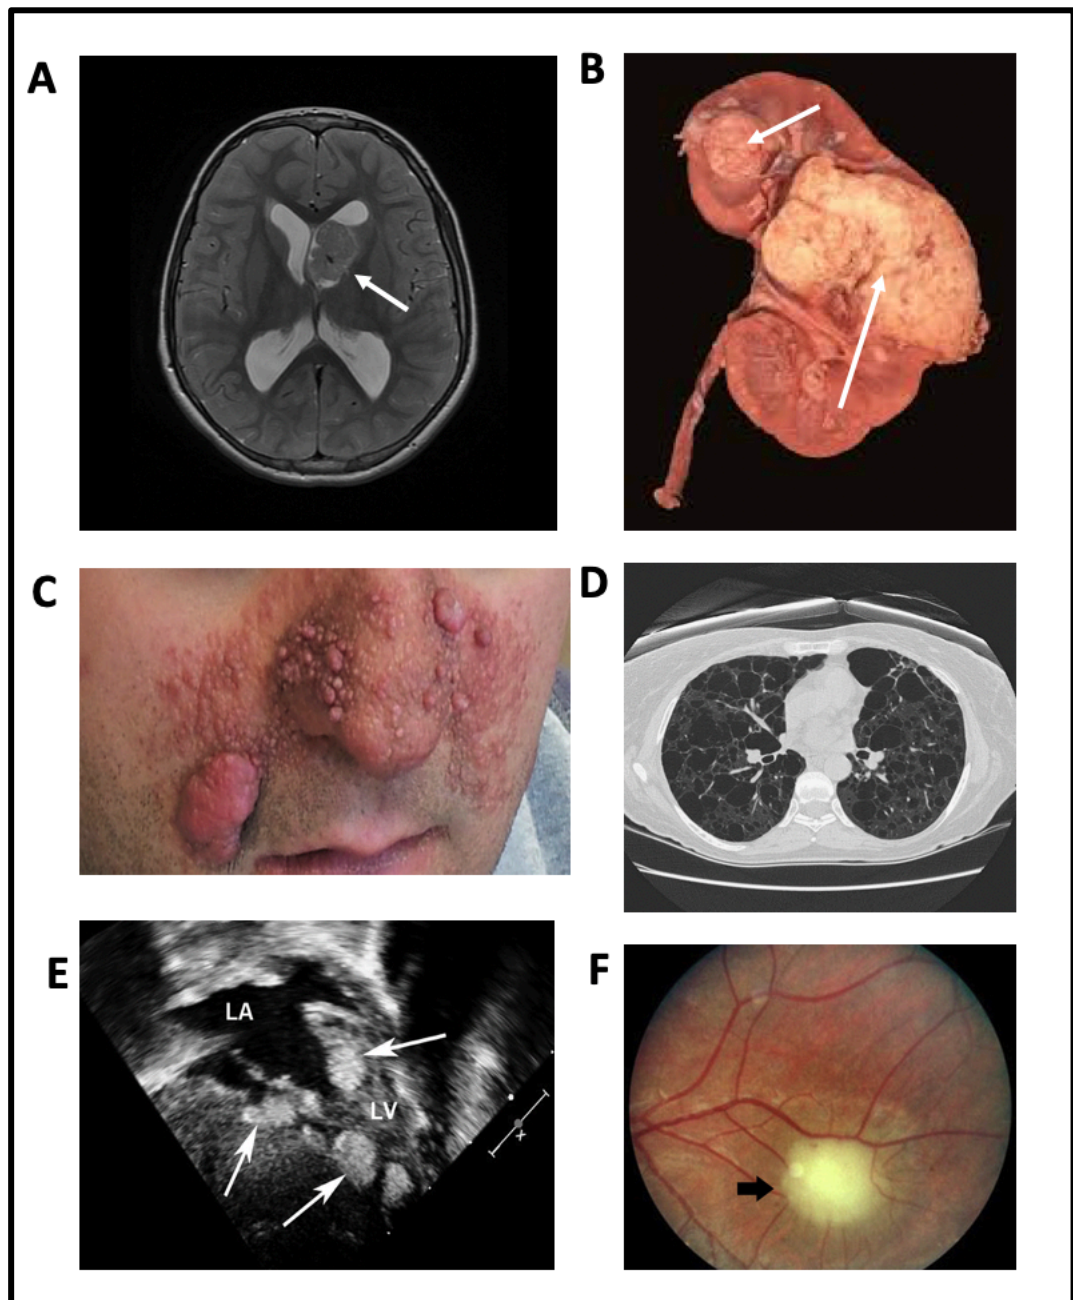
Clinical manifestations of TSC. (A) Brain MRI highlighting SEGA (white arrow). (B) Angiomyolipoma of a human kidney (white arrows). (C) Facial angiofibromas of a male with TSC. (D) Chest CT scan of a patient with LAM. (E) Fetal echocardiogram showing cardiac rhabdomyomas (White arrows; LA: Left Atrium; LV: Left Ventricle). (F) Retinal hamartoma in the eye of a TSC patient (Northrup et al. 2013)
